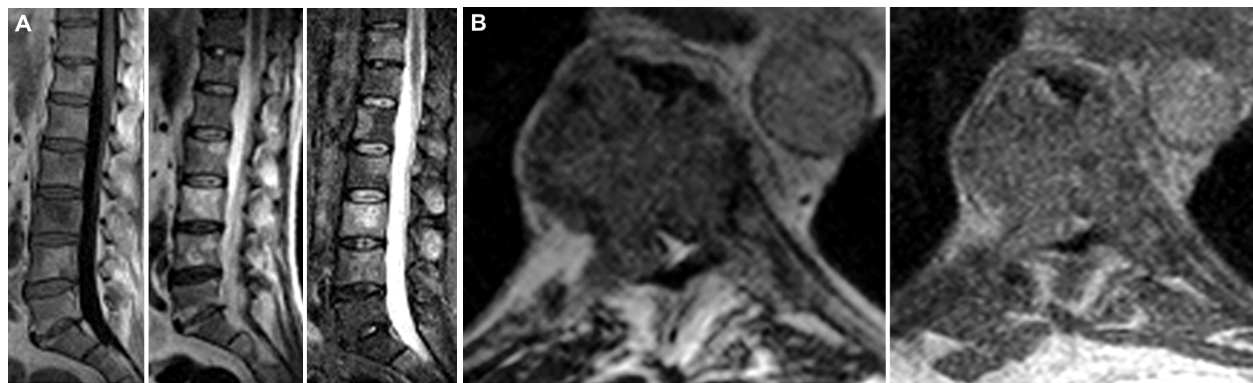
(A) Lumbar spine MRI: T1 and T2-weighted sequences, and STIR sequence – bone determinations which affect only the vertebral bodies at a patient with MH; (B) Thoracic spine MRI: T1-weighted sequence, pre- and post-contrast – metastases on vertebral body and right pedicle. MRI: Magnetic resonance imaging; STIR: Short-tau inversion recovery; MH: Malignant hemopathy.
